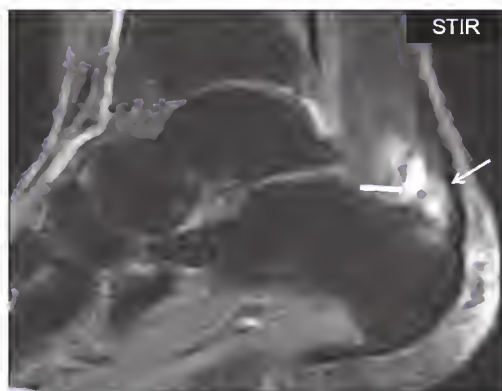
Magnetic resonance image showing enthesitis (right arrow) and bursitis of the subachilleal bursa (left arrow) in a patient with peripheral spondyloarthritis.
